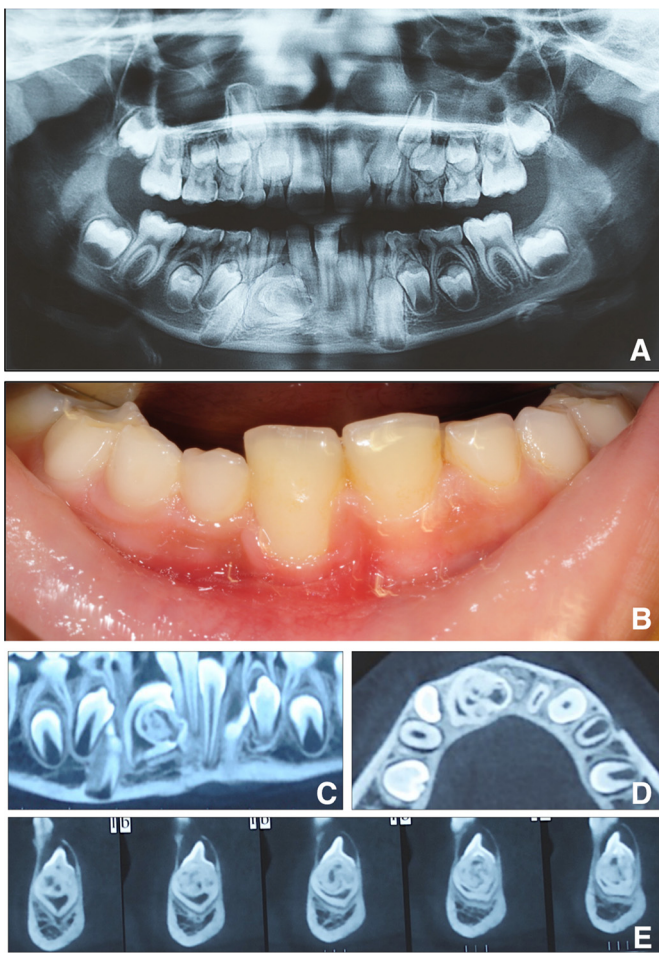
(A) Panoramic X-ray findings at the first visit. (B) Intraoral clinical photograph at the first visit. (C) CBCT Panoramic view. (D) CBCT Axial view. (E) CBCT Coronal view. CBCT findings showing a well circumscribed shell shaped with a complex hypodense/hyperdense anatomy.
